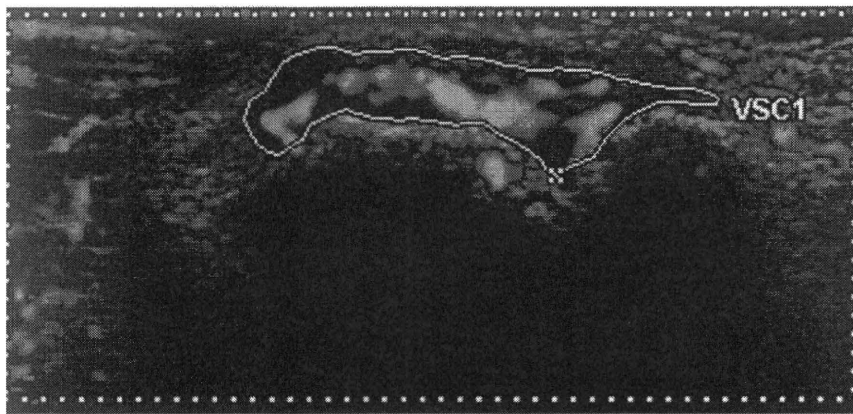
An actual image of joint ultrasonography (metacarpophalangeal joint of left second finger). Each joint was scanned as described in the “Materials and methods”. The area of the synovium was encircled by a white line drawn in free-hand line, then measured as
